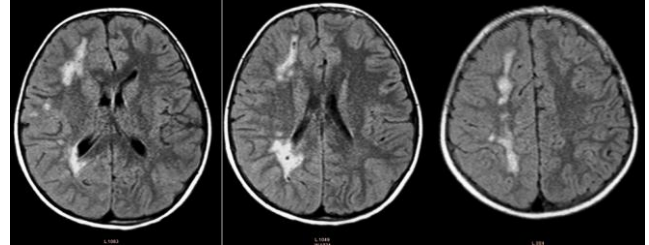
T2-weighted Flair (Fluid-Attenuated Inversion Recovery) images, unenhanced brain MRI
